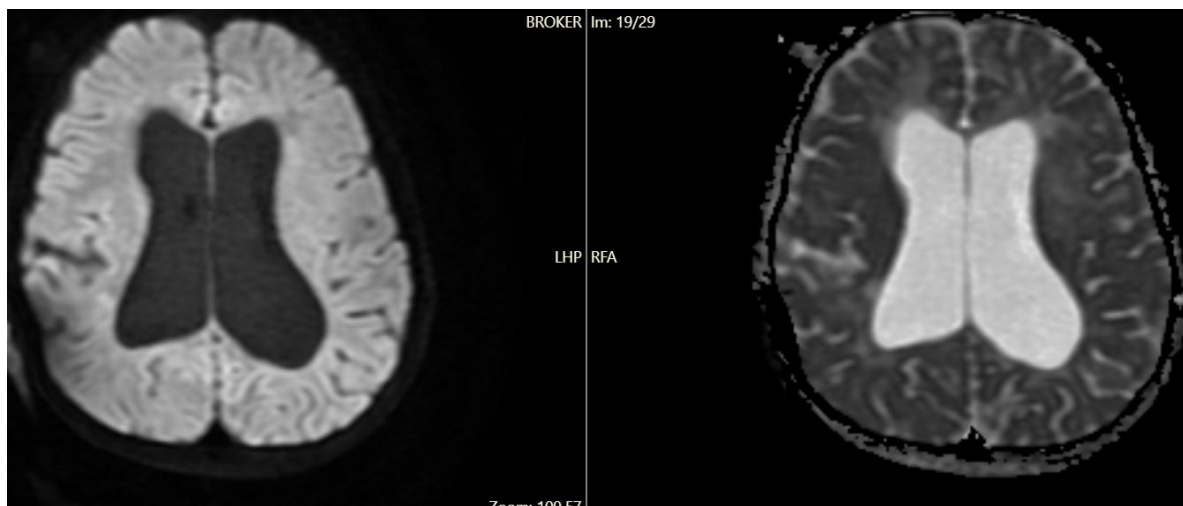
Diffusion-weighted imaging (DWI, left) and apparent diffusion coefficient (ADC) map (right). The periventricular white matter lesions show no restricted diffusion on DWI, with corresponding facilitated diffusion (bright signal) on the ADC map, consistent with chronic demyelination rather than acute ischaemia.
